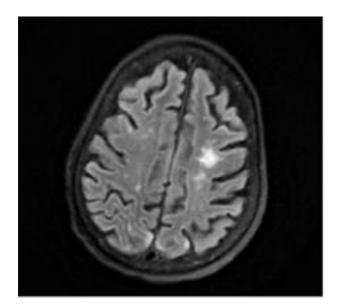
Brain MRI showing new areas representing subacute watershed infarctions with several punctate areas of acute infarction within the bilateral anterior cerebral artery/middle cerebral artery watershed territories.
